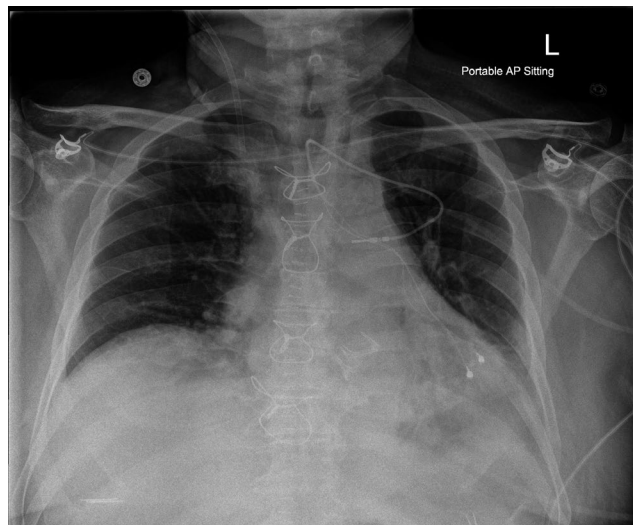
Postoperative chest X-ray after open-heart surgery in 2016 with aortic root replacement using a valve conduit and concomitant implant of a bipolar epicardial left ventricular lead with the silicone covered header placed in the subcutaneous tissue in the left pectoral area. No signs of damage to the epicardial lead at implant
